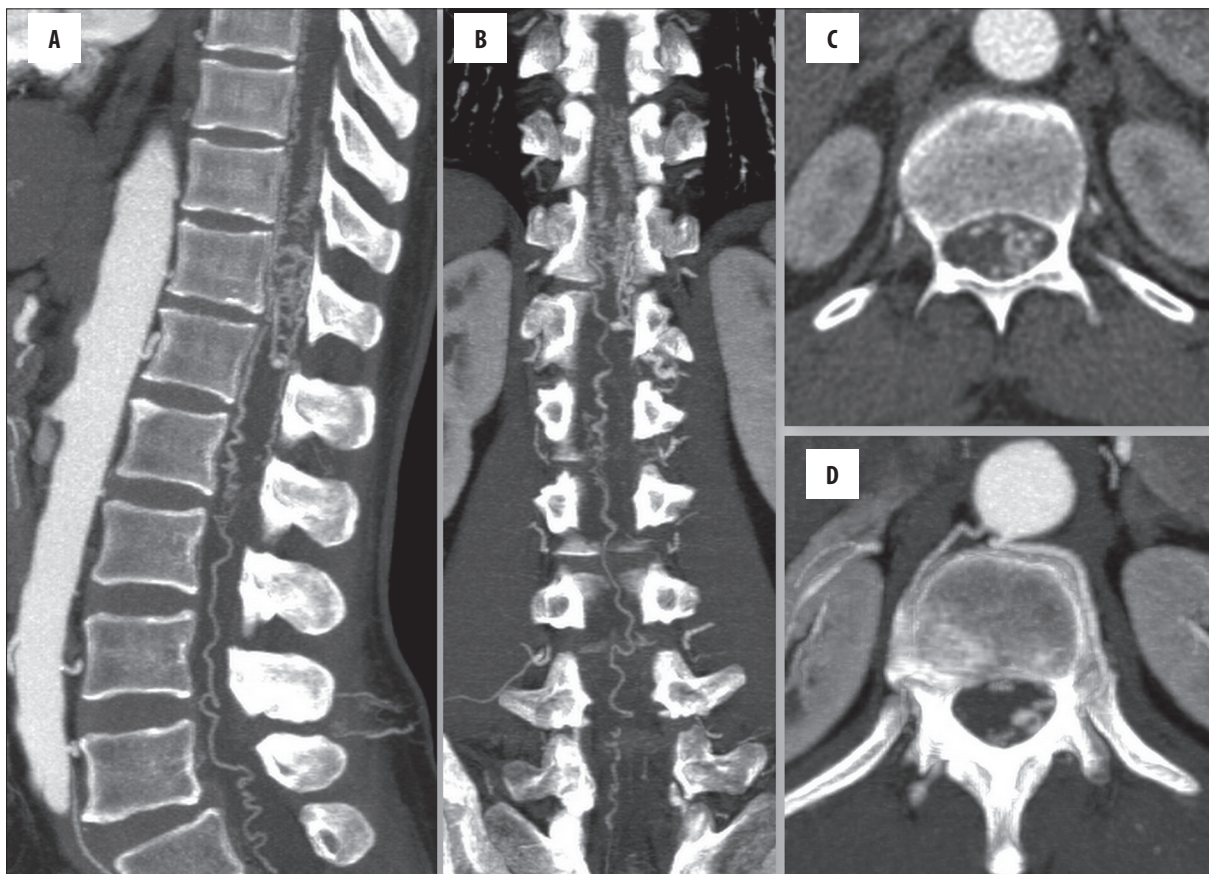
Sagittal (A), coronal (B) and axial (C, D) spinal computed tomography angiography images, maximum-intensity projection showing intradural AVM with cord displacement.
